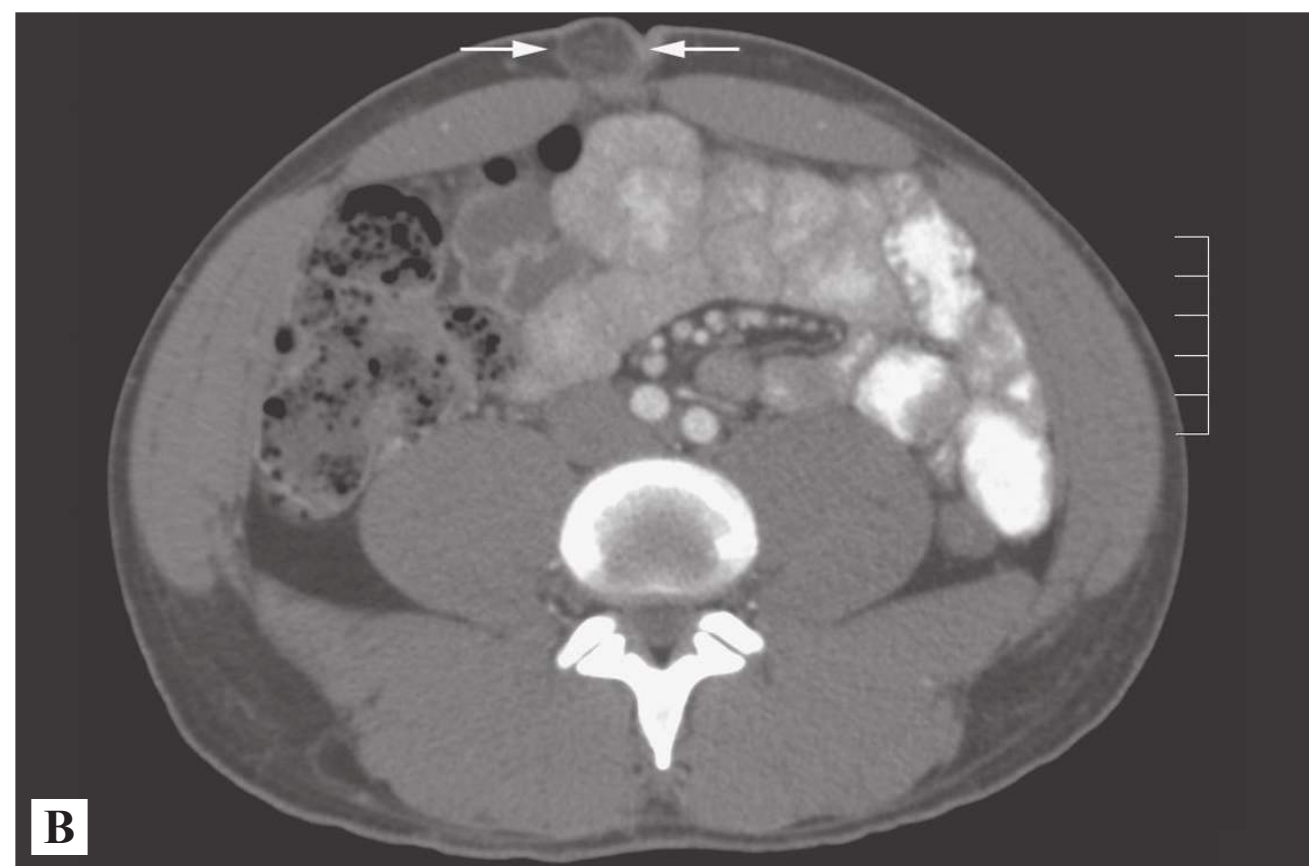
■ Umbilical Hernia CT Scan. CT reveals omentum in the umbilical hernia defect (arrows). (Photo Contributor: Lawrence B. Stack, MD.)
